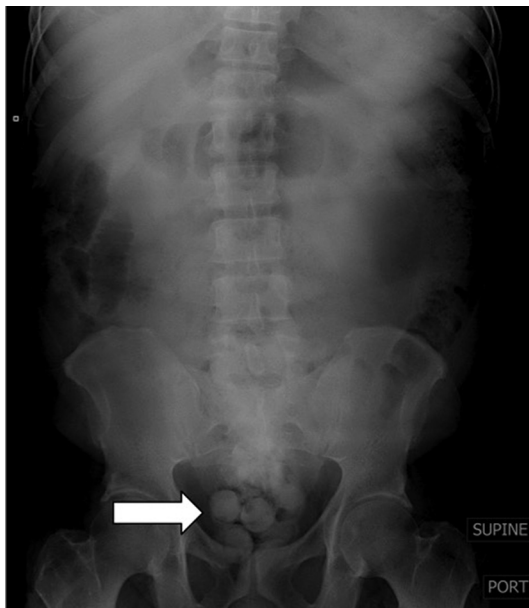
Portable supine anteroposterior radiograph of the abdomen demonstrates five similarly sized, uniformly dense rounded opacities clustered in the rectal region (arrow) suggestive of inserted foreign body material. Note that similar appearing foreign material is not apparent elsewhere in the stomach, small bowel, or more proximal colon.
